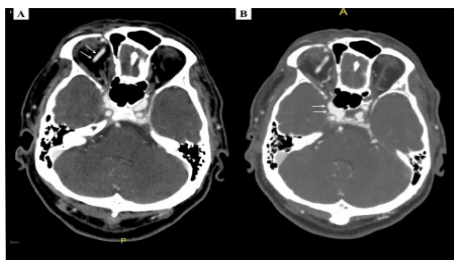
Computed tomography angiogram of the brain in axial view showing (A) dilated right superior ophthalmic vein and (B) enlargement of the right cavernous sinus (Source of Photo: Courtesy of Radiology Dept. Hospital of University Malaya).
